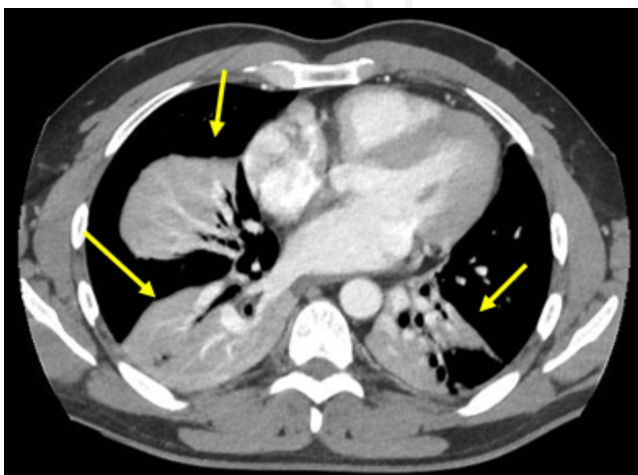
CT scan performed after 24 hours of NIV still showing basal bilateral atelectasis (yellow arrows). Note: CT: Computed tomography; NIV: Non-invasive ventilation.
